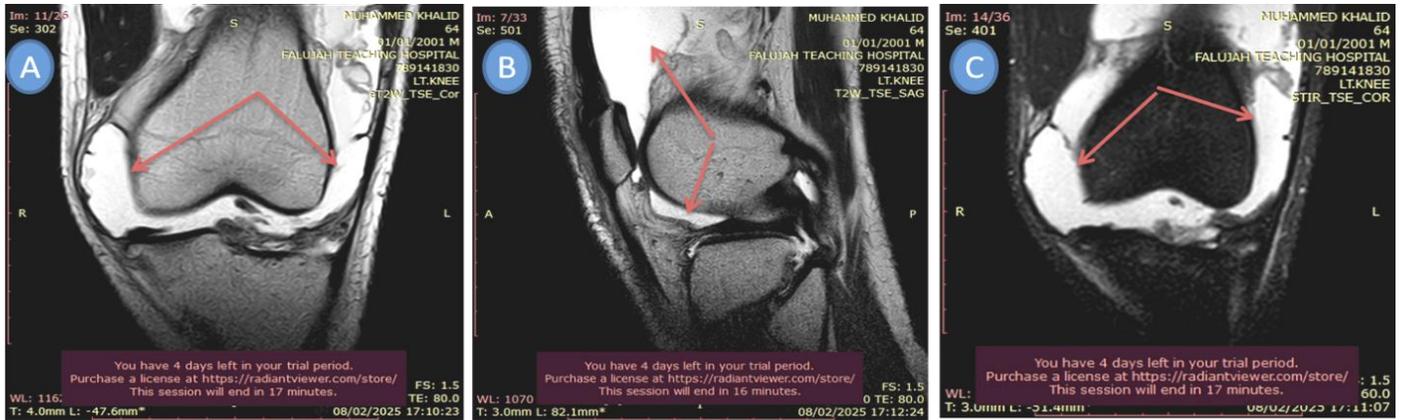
In each of A: T2 coronal, B: T2sagittal, C: STIR coronal showing fluid around knee joint (arrow) of MRI Knee joint.
